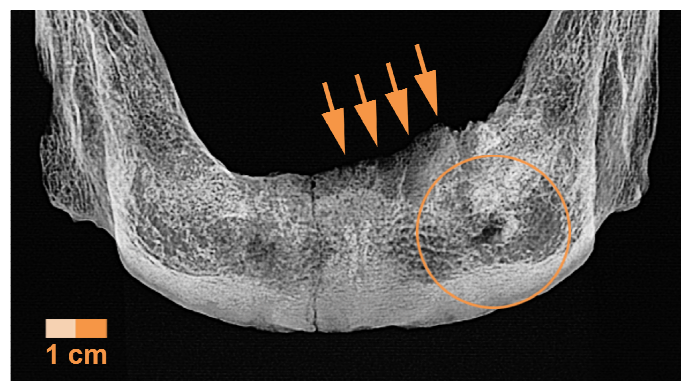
radiograph of anterior mandible, framing: periapical lesion, arrows: alveolar resorption and guttering
